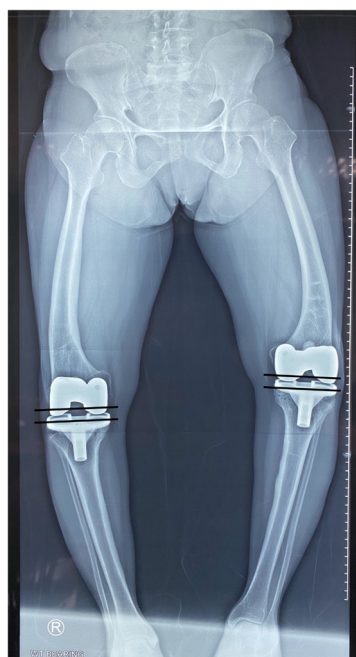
Standing x-ray of right and left lower limb with severe varus deformity. Unable to determine the anatomical axis of the femur due to its deformity.
